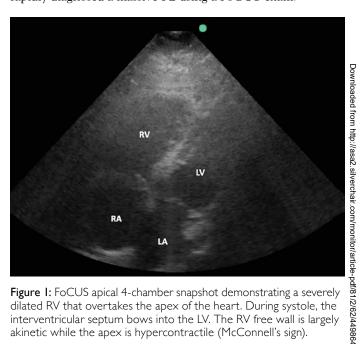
FoCUS apical 4-chamber snapshot demonstrating a severely dilated RV that overtakes the apex of the heart. During systole, the interventricular septum bows into the LV. The RV free wall is largely akinetic while the apex is hypercontractile (McConnell's sign).
